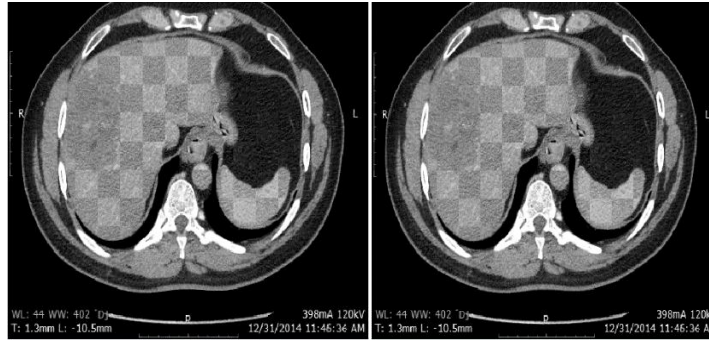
The second part is the number of the detected and the matches' values among the input of the registered images, with the MSER and the SURF calculated features. A. The registered image with both the phases, Triple phase CT and arterial phase. B. The registered image with the Triple phase CT and venous phase. C. The registered image with the Triple phase CT and the delayed. D. The registered image with both the Triple phase CT and the delayed 10 min. E. The registered image with both the arterial phase and the venous phase. F. The registered image with the arterial phase and the delayed. G. The registered image with the arterial phase and the delayed 10 min. H. The registered image with the venous phase and the delayed. I. The registered image with the venous phase and the delayed 10 min. J. The registered image with the delayed phase and the delayed 10 min. phase.
